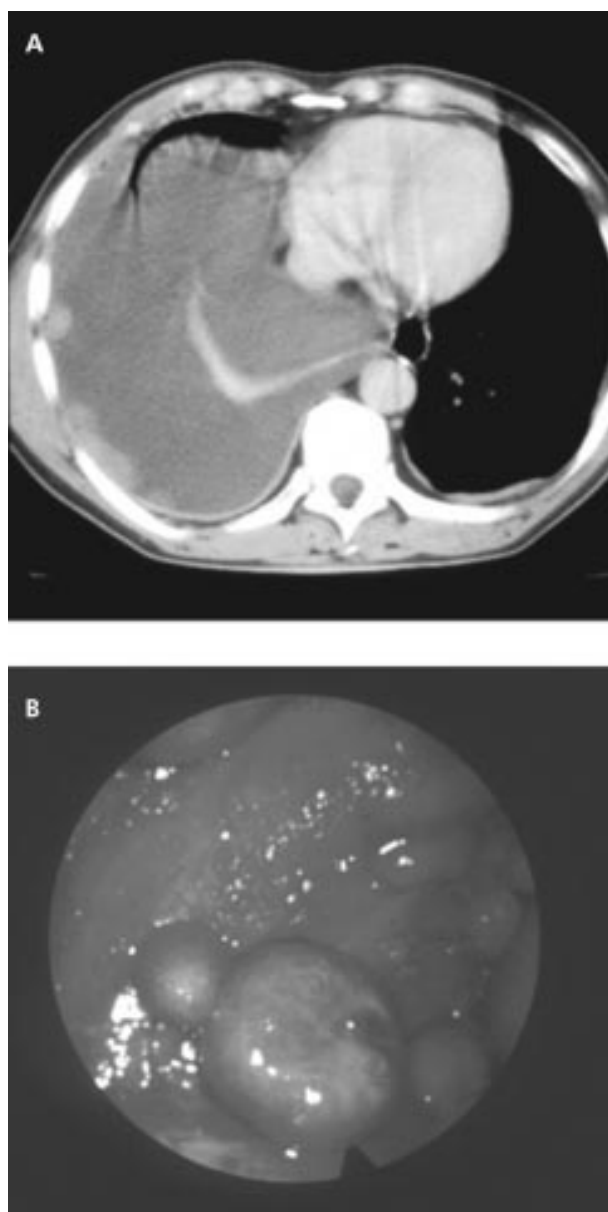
(A) CT scan and (B) thoracoscopic appearance of pleural malignancy (breast carcinoma metastases).
